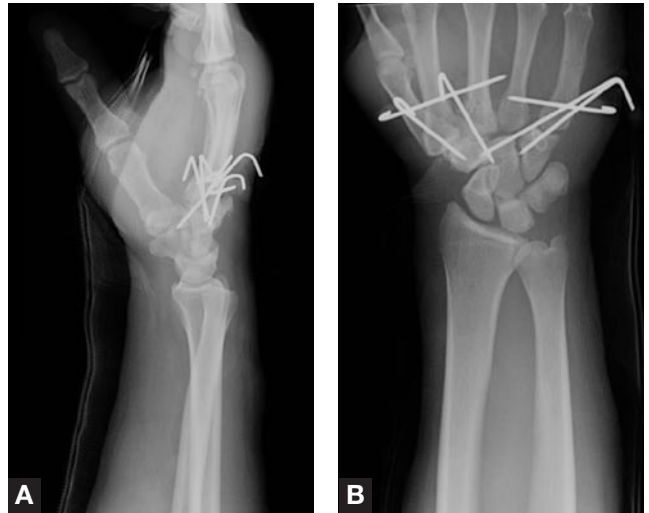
Final (A) lateral and (B) anteroposterior radiographic images show anatomical alignment of carpometacarpal joints after closed reduction and percutaneous pinning.
